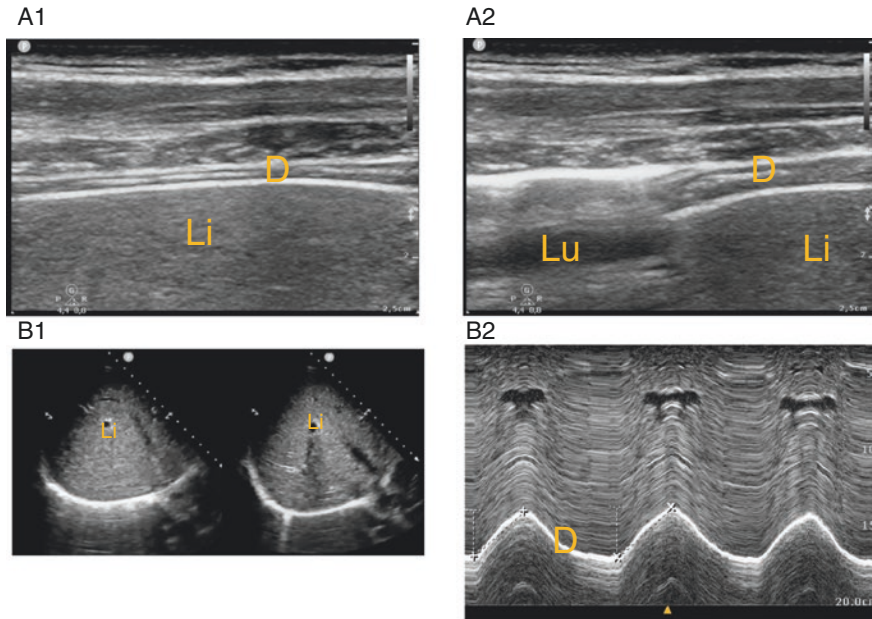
Diaphragm ultrasound. (a1) Diaphragm end expiration (B-mode). (a2) Diaphragm end inspiration (B-mode). (b1) Diaphragm excursion (B-mode). (b2) Diaphragm excursion (M-mode). *D* Diaphragm, *L* Lung, *Li* Liver
